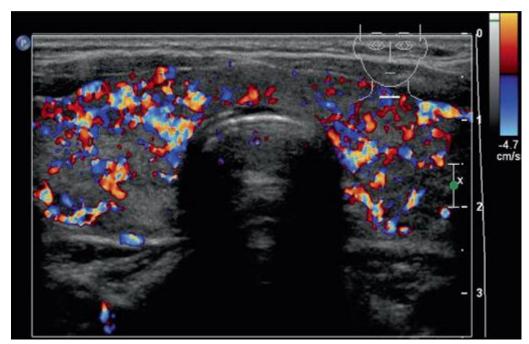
Qualitative Doppler Assessment (Diffusely Increased Vascularity, Pattern II).
